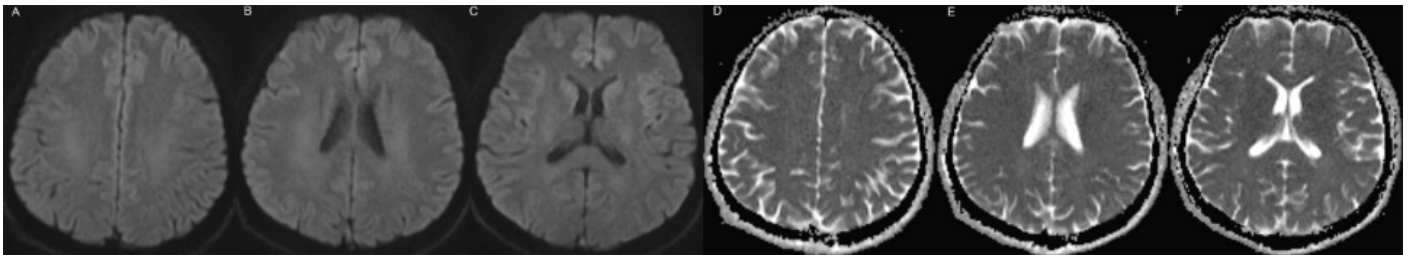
Repeated brain magnetic resonance imaging (day 29). Axial (A, B, and C) diffusion-weighted images and (C, D, and E) apparent diffusion coefficient maps show the complete resolution of the diffusion restriction
